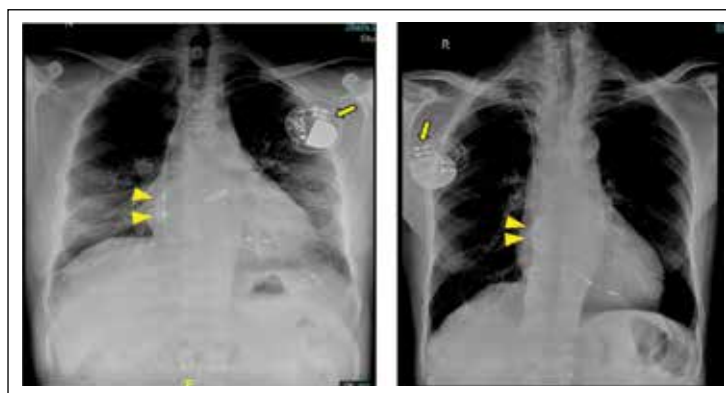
Frontal radiographs showing the VDD lead, i.e., a lead that can sense events in two chambers but with a pacing function confined to the ventricle. Currently, these leads are not being used. Two extra electrodes can identify these leads with contact over the lateral RA wall (arrowheads) and two connector ports in the pulse generator header (arrow).
